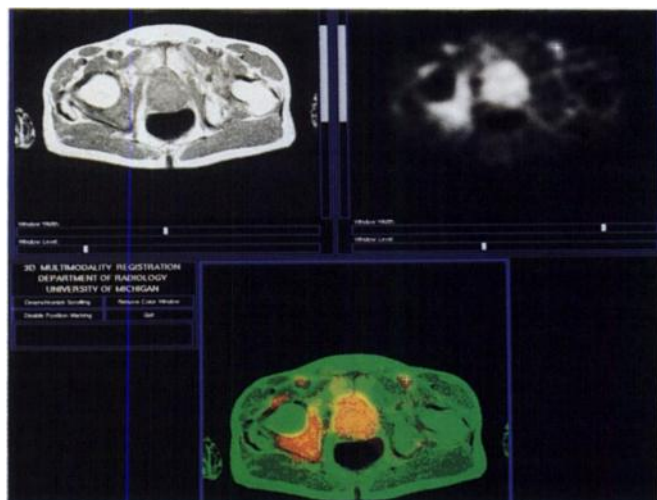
T1-weighted MRI (TR 600, TE 20) demonstrates abnormal signal intensity in the region of the right acetabulum in this patient with metastatic prostatic carcinoma to bone. Emission PET demonstrated two foci of FDG activity, one in the midline and one to the right of midline. Fusion images demonstrated that the focal uptake in the midline was in the region of the prostate gland (the patient had residual prostate carcinoma in the gland), and the signal from the right of midline fused into the area of abnormal MR signal (metastasis) located in the right acetabulum. Fidelity of the fusion was further substantiated by the fact that the two faint foci of FDG uptake located anterior and to either side of the prostate were seen at multiple levels on PET (i.e., were tubular) and fused into the location of the external iliac blood vessels.
